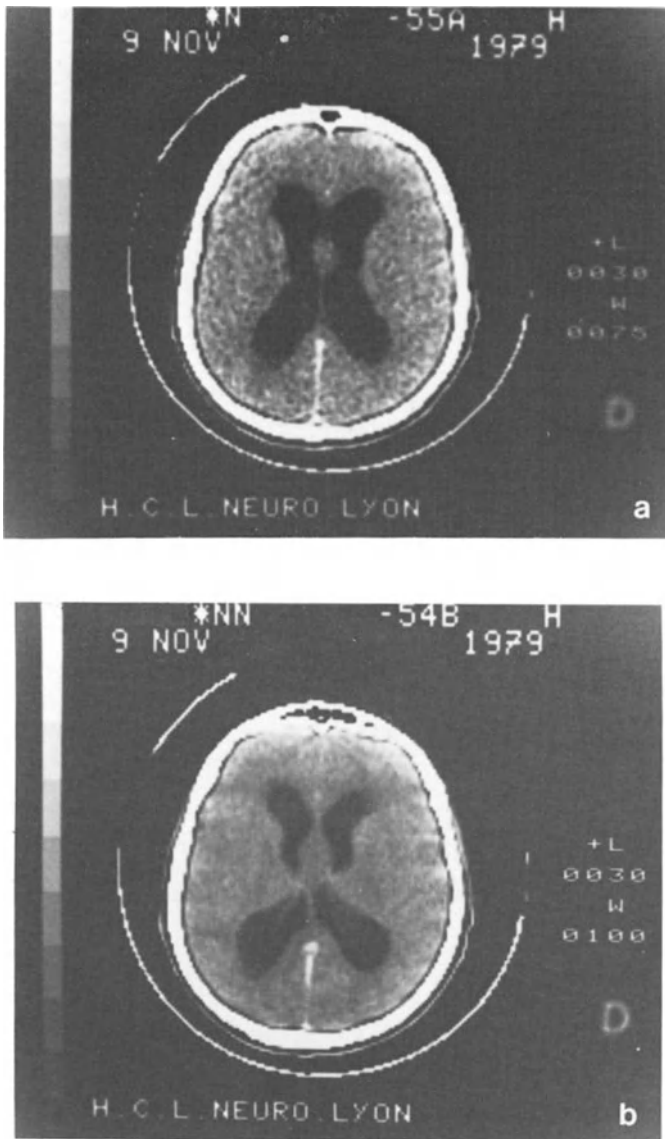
Grade I septum pellucidum astrocytoma causing symmetric hydrocephalus. Both figures a and b are post-contrast CT studies
